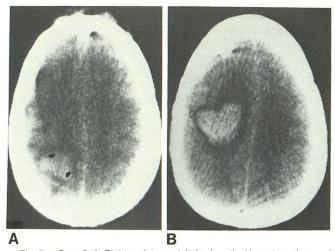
Case 5. A, Right parieto-occipital subcortical hematoma (*arrows*) seen immediately after trauma. Adjacent increased density in cortex due to extravasated or static blood secondary to contusion. B, CT study 2 days later. Large delayed hemorrhage and edema in right centrum semiovale. Lesion extends to medial and lateral (*arrows*) subcortical borders of right parietal lobe.
